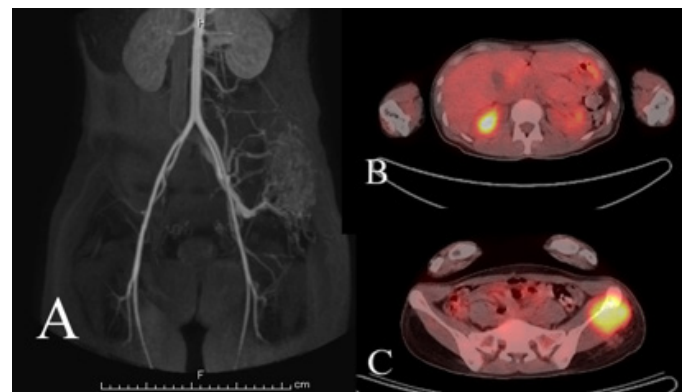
MRA image showing tumor hypervascularity in tumor of the left ilium (A). ¹⁸F-FDG PET-CT image demonstrating increased FDG uptakes in the right kidney (B) and left ilium (C). The SUV_{max} values are 8.1 (B) and 4.8 (C), respectively.
